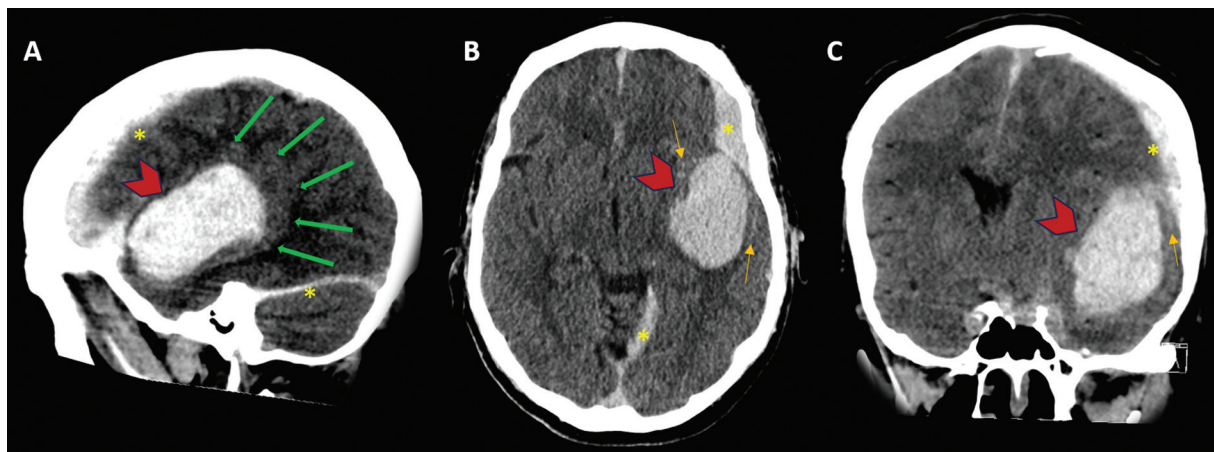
Head CT without IV contrast immediately after patient’s severe headache. Interval large acute hematoma along the left sylvian fissure, probably in the subpial compartment (red arrowheads). There was local mass effect with adjacent opercular cortex compression (green arrows). Small component of subdural (yellow asterisks) and subarachnoid (orange arrows) hemorrhages were also visualized.
